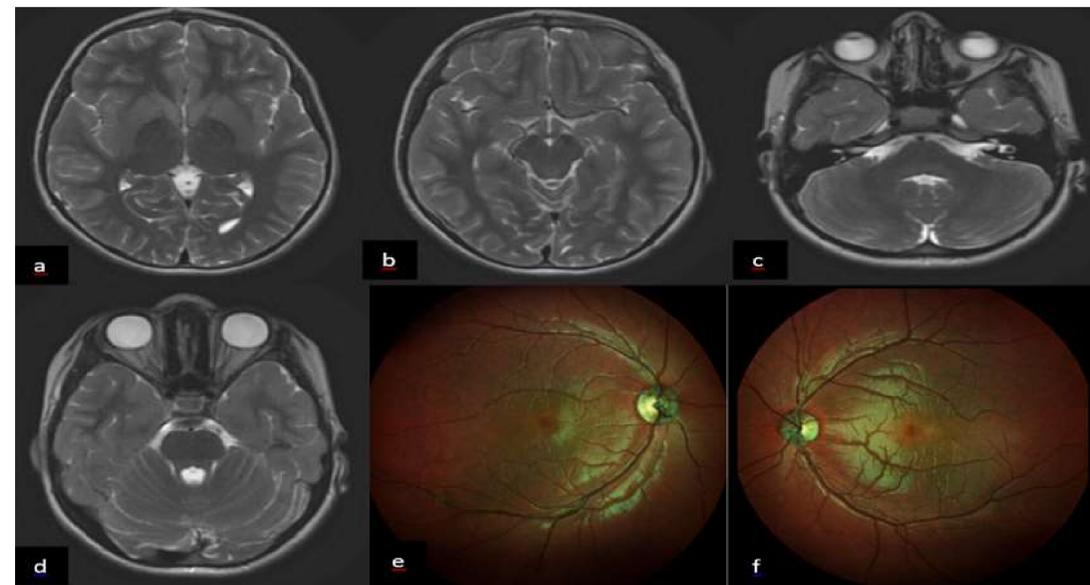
Cranial magnetic resonance imaging of Case 2, hypointensities in the globus pallidus (a), substantia nigra, red nucleus (b), and dentate nucleus (c), thinning of the optic nerves (d) on T2 weighted images. Optic atrophy on the right (e) and left (f) fundus photograph.
